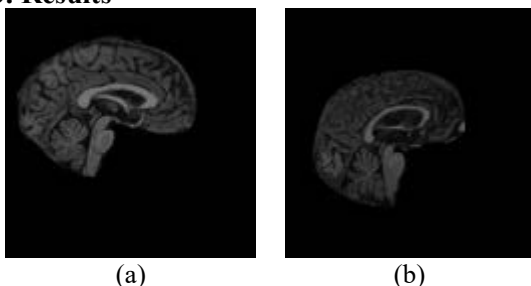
Representative sagittal view T1-weighted brain MR images of (a)CN and (b)AD subjects
